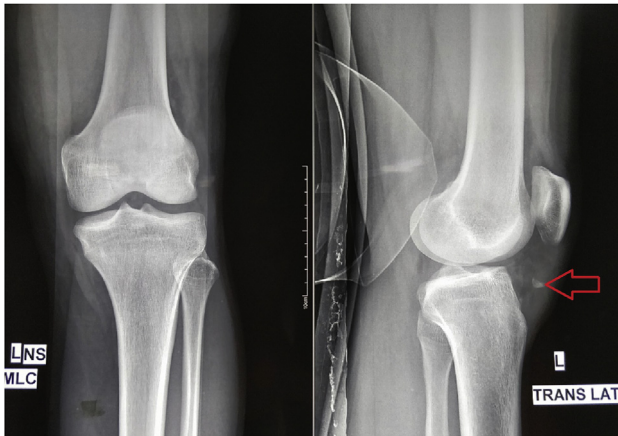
X-ray of left knee AP & Lateral view (Arrow) showing bony avulsion fracture of inferior pole of patella: suggestive of patellar tendon avulsion.
